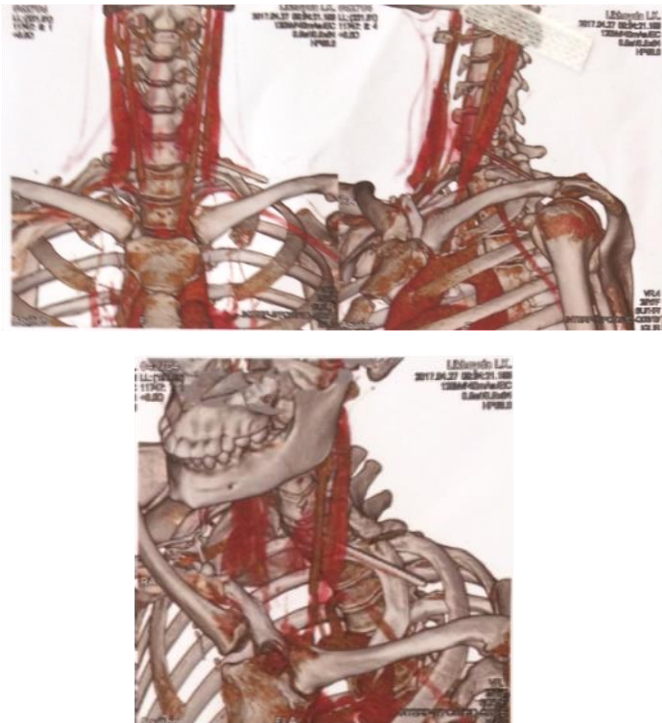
CT scans visualizing a foreign body (Kirschner's wire) in the left supraclavicular region.
